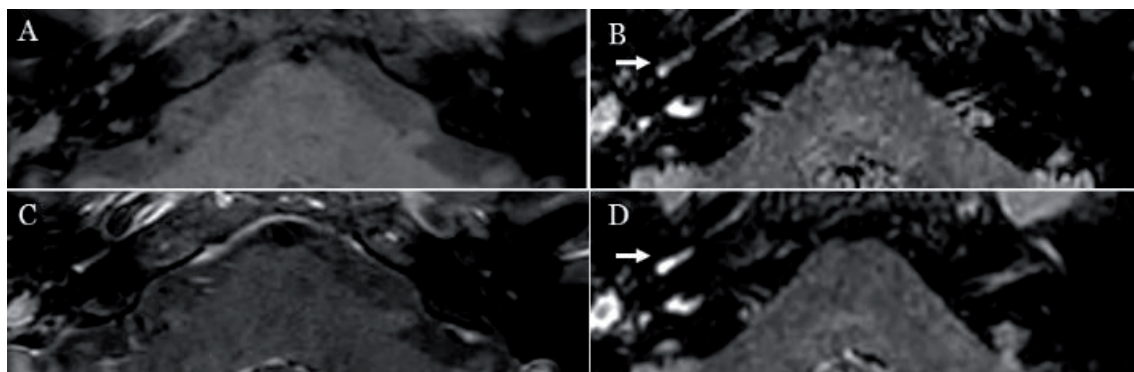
Inflammatory pattern of SSSL. The pre-contrast T1w (arrow, A) shows no signal abnormalities. The pre-contrast 3D-FLAIR (arrow, B) shows a high signal in the basal turn of the right cochlea. A postcontrast T1-w sequence (arrow, C) does not show enhancement, whereas a postcontrast 3D-FLAIR sequence (arrow, D) shows the basal turn of the cochlea markedly enhanced on the right side.
